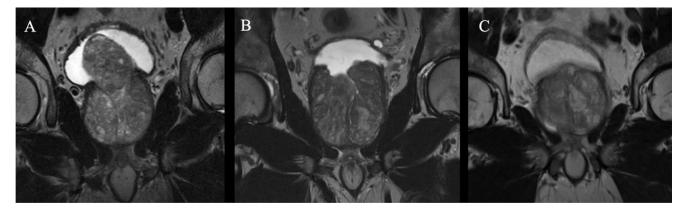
Coronal T2 MR images of 3 different patients demonstrating (A) median lobe enlargement, (B) lateral lobe enlargement, and (C) trilobar enlargement.
